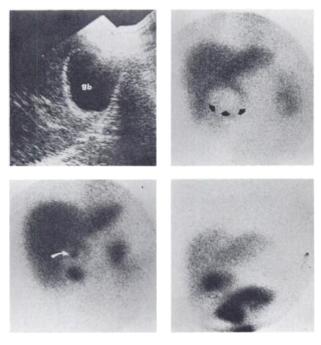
Case 2. Sonogram (upper left): distended, ovoid gallbladder (gb) without evidence of stones or debris. Tc-HIDA scintigram: 1 hr (upper right): large, photon-deficient gallbladder fossa (arrows). 2.5 hr (lower left): partial filling of gallbladder is seen (curved arrow). 8 hr (lower right): full size of gallbladder is shown (open arrow), corresponding to previously seen photon-deficient region.
